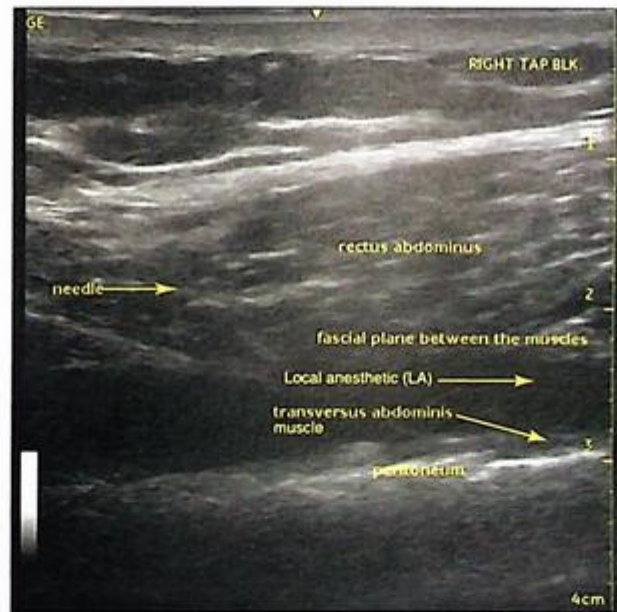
Ultrasound image of the subcostal transversus abdominal plane (TAP) block with needle.
